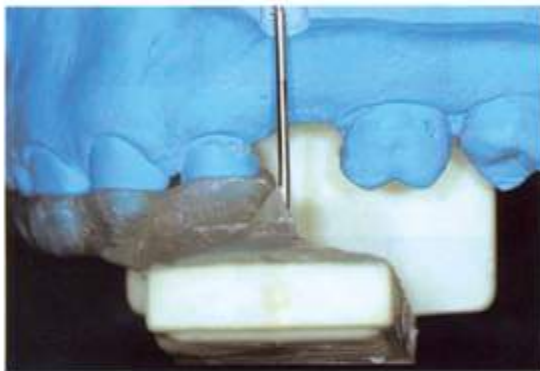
The radiographic stent is fabricated, incorporating a radiopaque post and a film holder.
